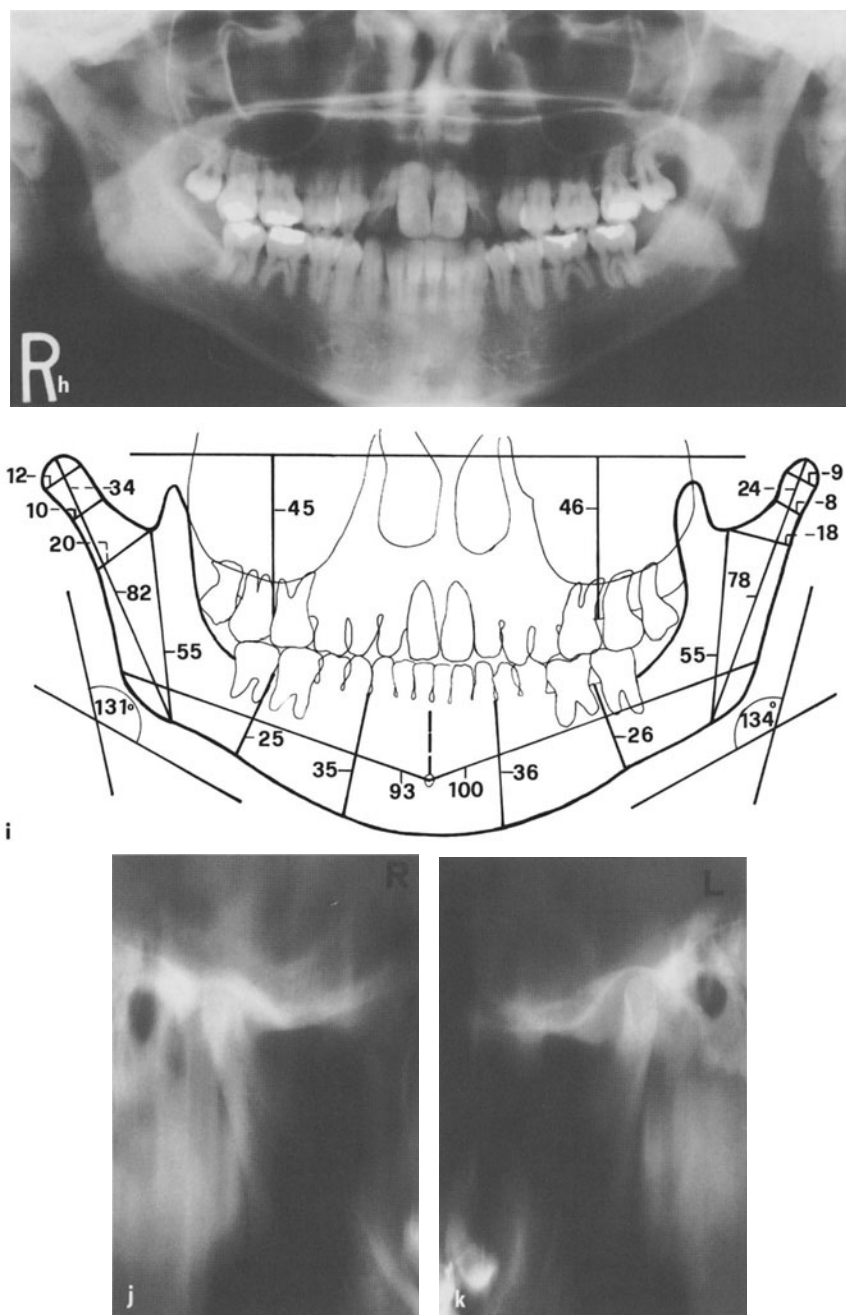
Bilateral H.E., slender type, active during puberty. h The panoramic radiograph discloses the two long articular processes with small condyles and stretched angles and the resulting asymmetry. i The measurements of the tracing of the panoramic radiograph show that the differences between the two sides are larger than expected. j, k The TMJ–ramus tomograms show very clearly that both condyles are rather small compared with normal. They also show the very long slim necks on both sides
